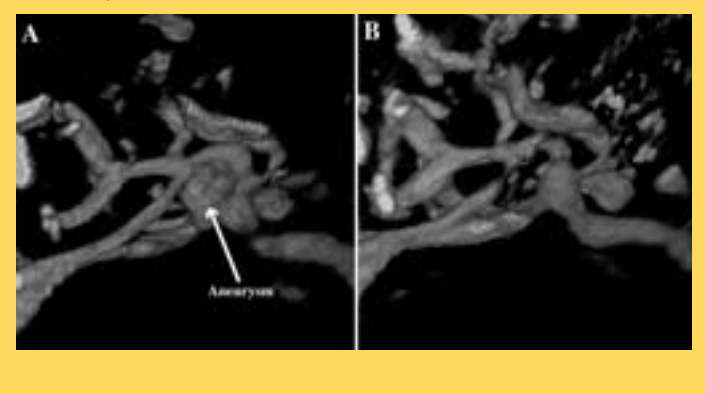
(below right): 3-D ultrasound angiography (USA) in aneurysm surgery. Volume rendering of USA data acquired just before the clipping (A) of the aneurysm (arrow) and right after the clipping (B). The aneurysm is seen in the middle of picture A) whereas it has been removed in B). Both A) and B) is rendered with the same view
